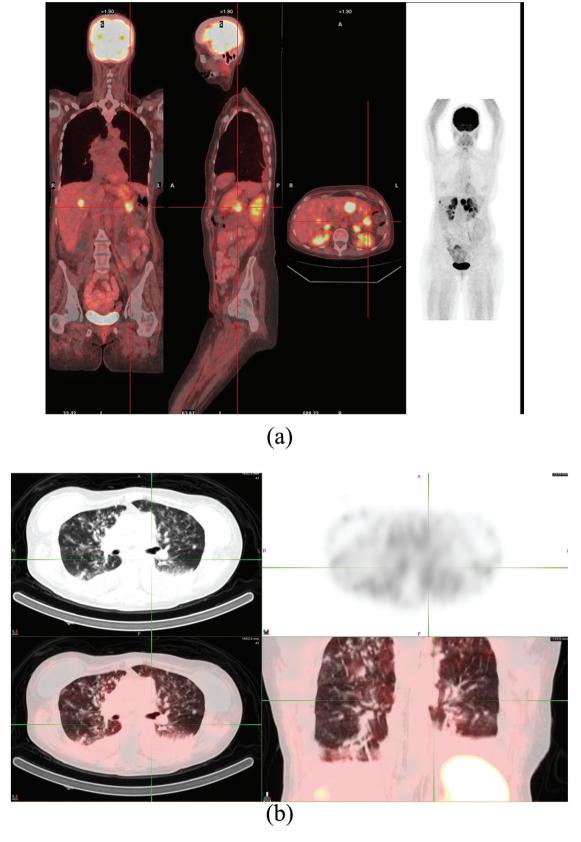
18-Fluorodeoxyglucose positron emission tomography and computed tomography scan images at the time of initial diagnosis revealed abnormal radiotracer uptake in the tail of the pancreas and liver (a). A repeat scan approximately 6 weeks later at the time of hospital admission showed multiple bilateral hypermetabolic pulmonary nodules (b).
